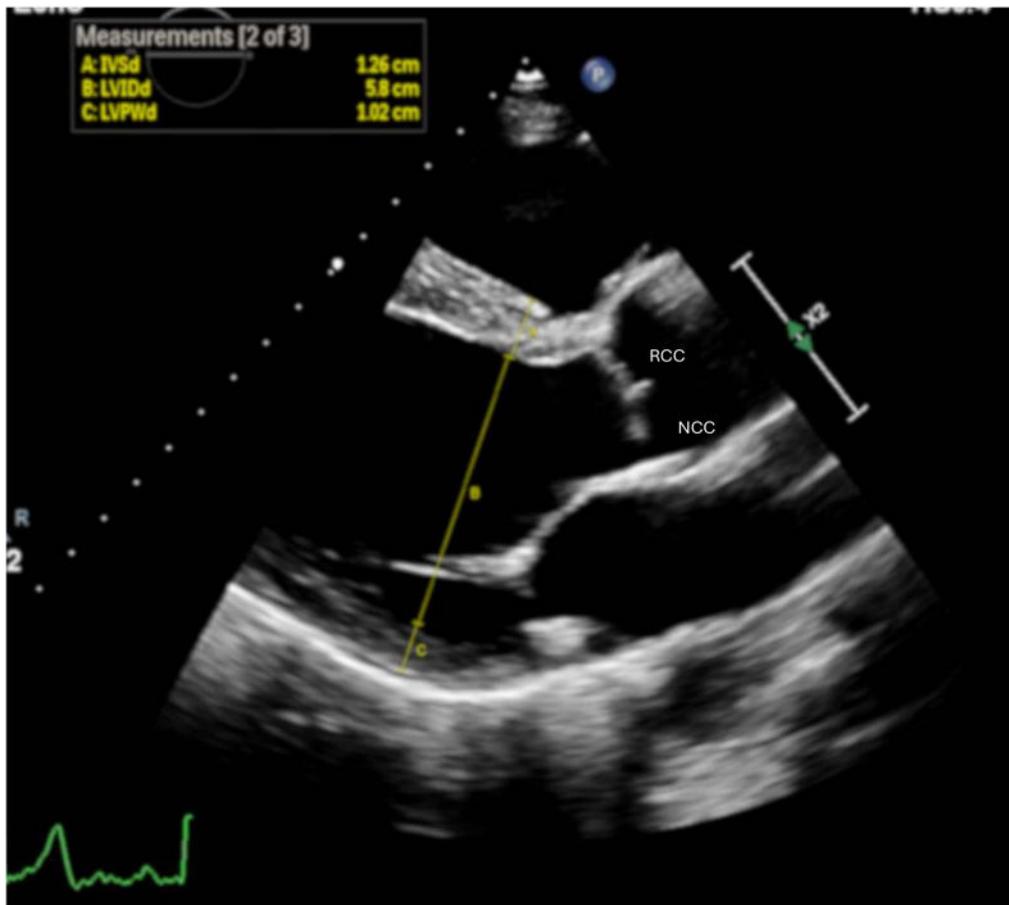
Parasternal long-axis (PLAX) showing location of measurement for left ventricular internal diastolic diameter (LVIDd; yellow line), right coronary cusp (RCC), and non-coronary cusp (NCC).
